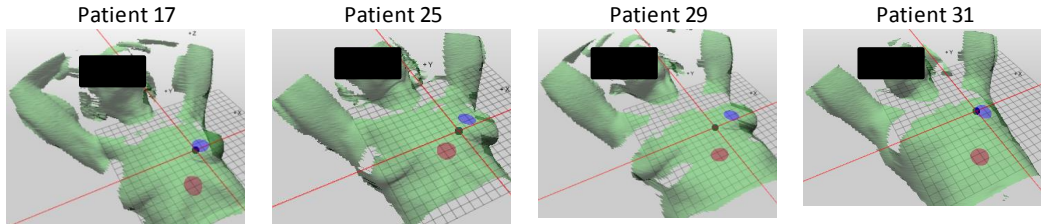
The surface acquired before planning CT with the gating area (red) used to monitor the respiratory motion in the vertical direction. The blue area was also monitored passively but not used in the current study. Preferably, the area above the xiphoid process was used as gating area (Patient 17 and 25). If the signal reception was inadequate, the gating area was moved slightly laterally and caudally (patient 29 and 31).
